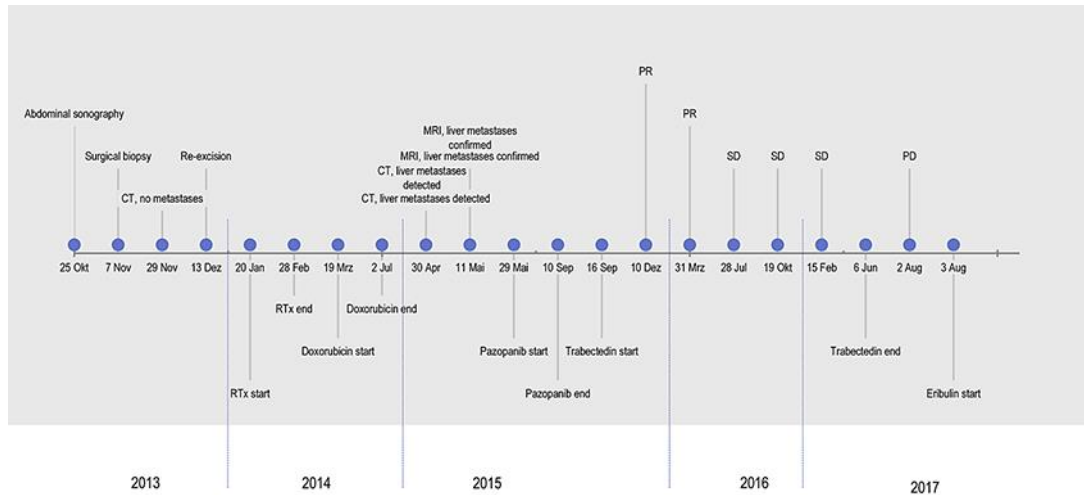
Overview of diagnostic and therapeutic measures and outcomes over time. CT, computed tomography; MRI, magnetic resonance imaging; PD, progressive disease; PR, partial remission; RTx, radiotherapy; SD, stable disease.
